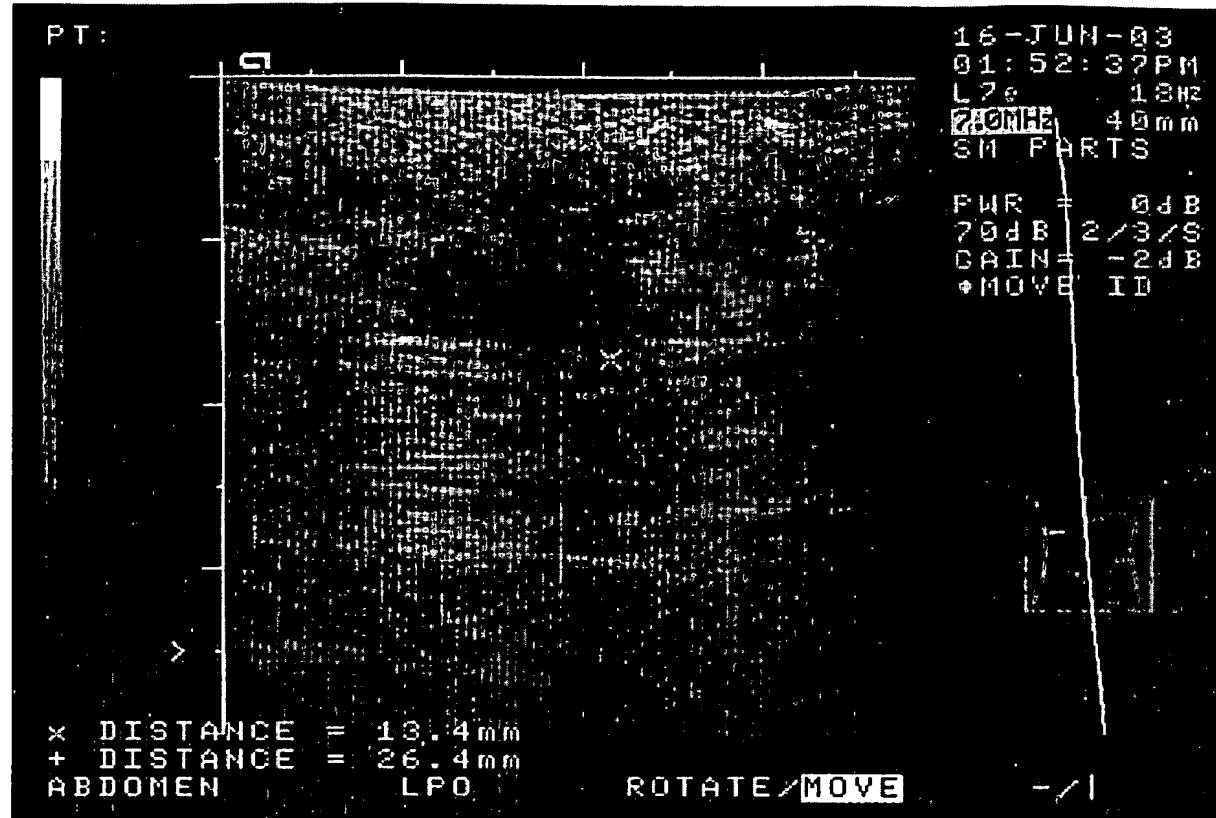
Ultrasonic scanning pattern of the formed depot of PAAG after one day subsequent to insertion.
